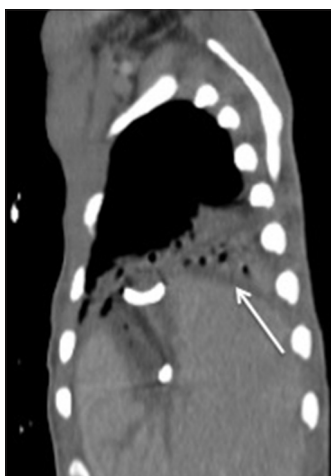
Sagittal image of a computed tomography (CT) of the chest performed 4 days after the study in Figure 1 demonstrates development of a new right lower lobe consolidation (thin arrow). A partially visualized drain terminates in the hepatic dome abscess. Biliptysis presented 2 days after this CT was performed
